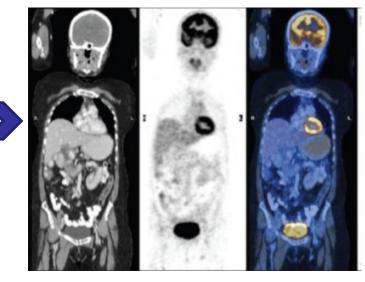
Image reconstruction and corrections (eg. decay, motion) CT
